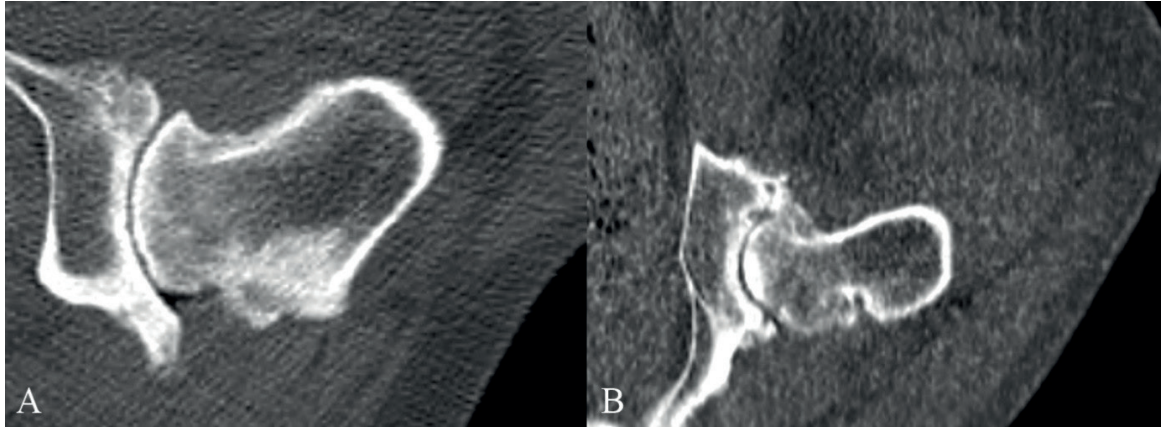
Transversal (A) and dorsal (B) right pelvic CT image of 11 years old Kangal with marked osteoarthritis. diffuse sclerosis of the caput femoris and acetabulum.
